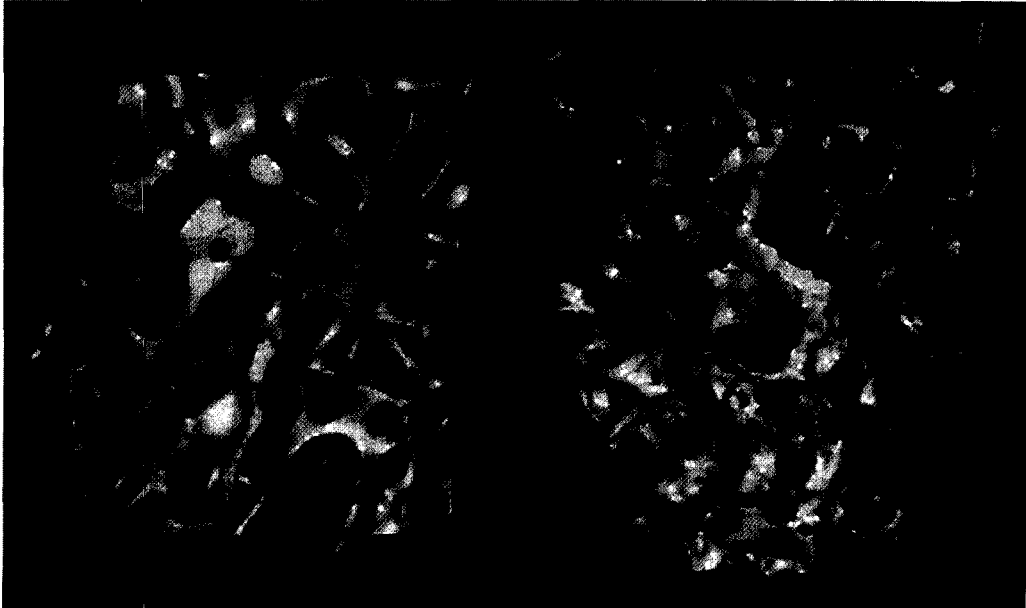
μ CT images of trabecular structure of human iliac. At the right the loss of mineralized bone substance with progressing osteoporosis is evident.
